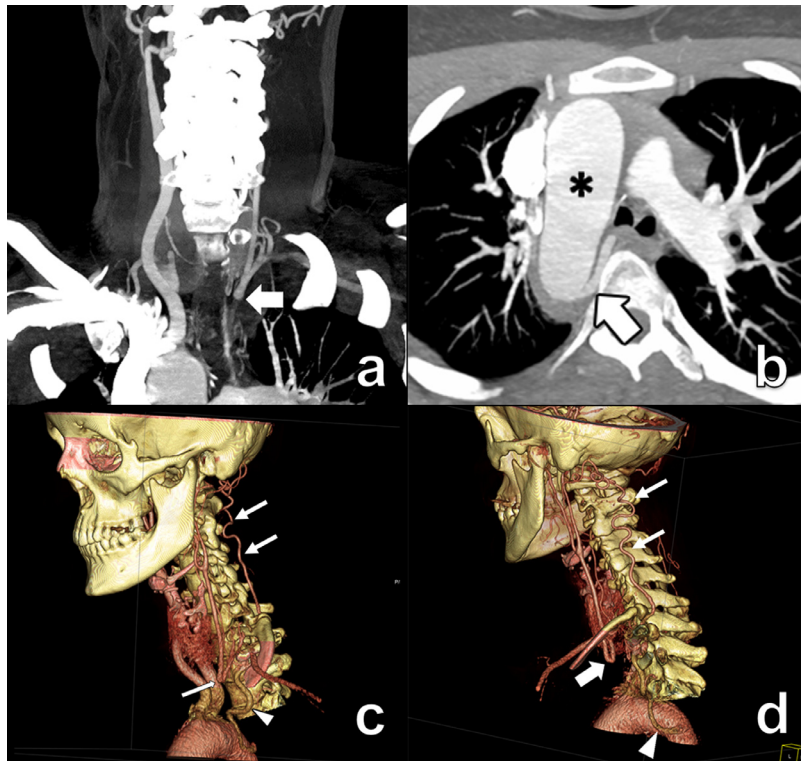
Right aortic arch with mirror image branching type and interrupted left BCA in a 35-year-old female. (a) AP—Reformatted frontal CT with angiographic reconstruction shows isolated left brachiocephalic artery (arrow). (b) Axial CT with maximum intensity projection demonstrates a right aortic arch (asterisk) with a large posterior mediastinal collateral artery (arrow) arising from its posteromedial border. (c) LAO—Left anterior oblique 3D volume rendered reformatted CT angiographic projection shows isolated left brachiocephalic artery (arrow) and large posterior mediastinal collateral artery (arrowhead) arising from the aorta. (d) LPO—Left posterior oblique 3D volume rendered reformatted CT angiographic projection shows isolated left brachiocephalic artery (arrow) and large posterior mediastinal collateral artery (arrowhead) arising from the aorta.
